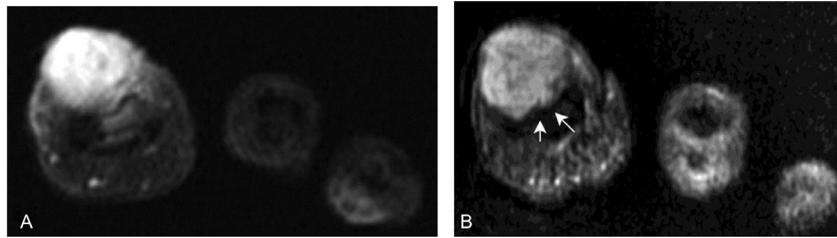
Myxoid dermatofibroma. (A) Coronal short-axis fat saturated T2WI shows a lobulated superficial mass in the dorsum of the first distal phalanx that has high signal intensity. (B) Coronal short-axis postcontrast fat saturated T1WI shows homogeneous contrast enhancement with bony erosion (white arrows). T1WI, T1-weighted images; T2WI, T2-weighted images.
